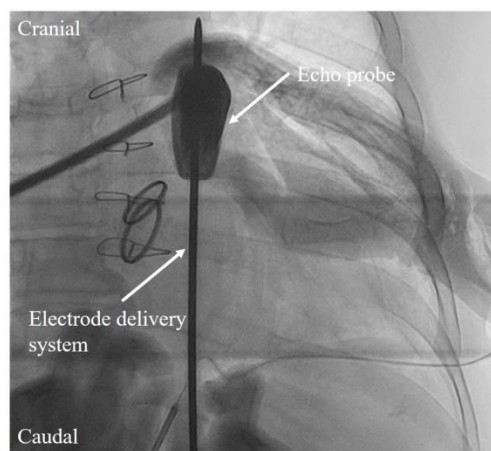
Fluoroscopic image during echo-guided parasternal tunneling using the electrode delivery system.
